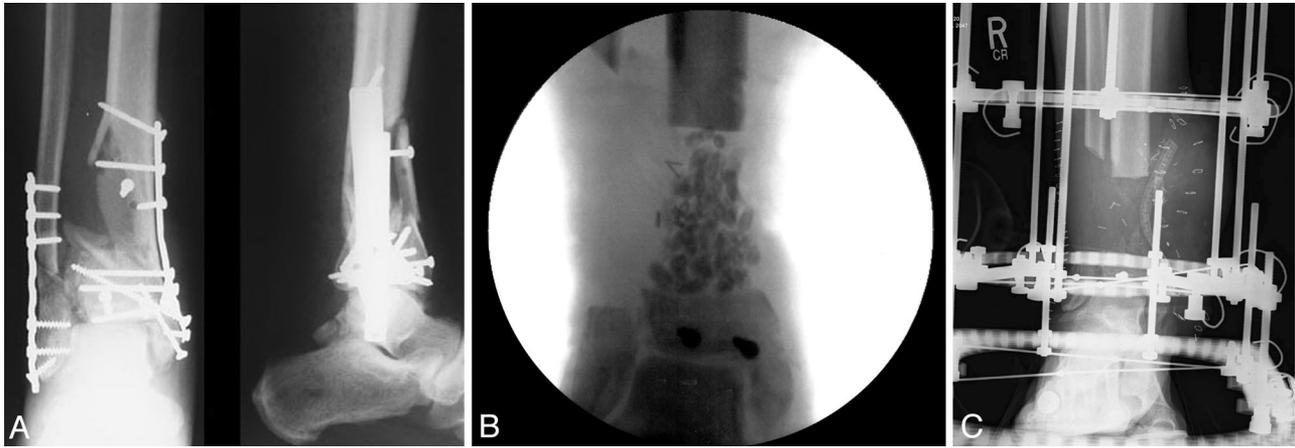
Partial bone loss. (A) Anteroposterior and lateral presenting radiographs of a 53-year-old man following multiple failed attempts at treatment after a severe right distal tibia fracture. The patient presented with this infected distal tibial nonunion with a large partial segmental bone defect following plate and screw fixation. (B) Anteroposterior radiograph showing the residual following bony debridement to two opposing flat surfaces and placement of antibiotic beads. (C) Anteroposterior radiograph showing the large circumferential segmental defect on postoperative day one with a planned reconstruction via Ilizarov bone transport.
